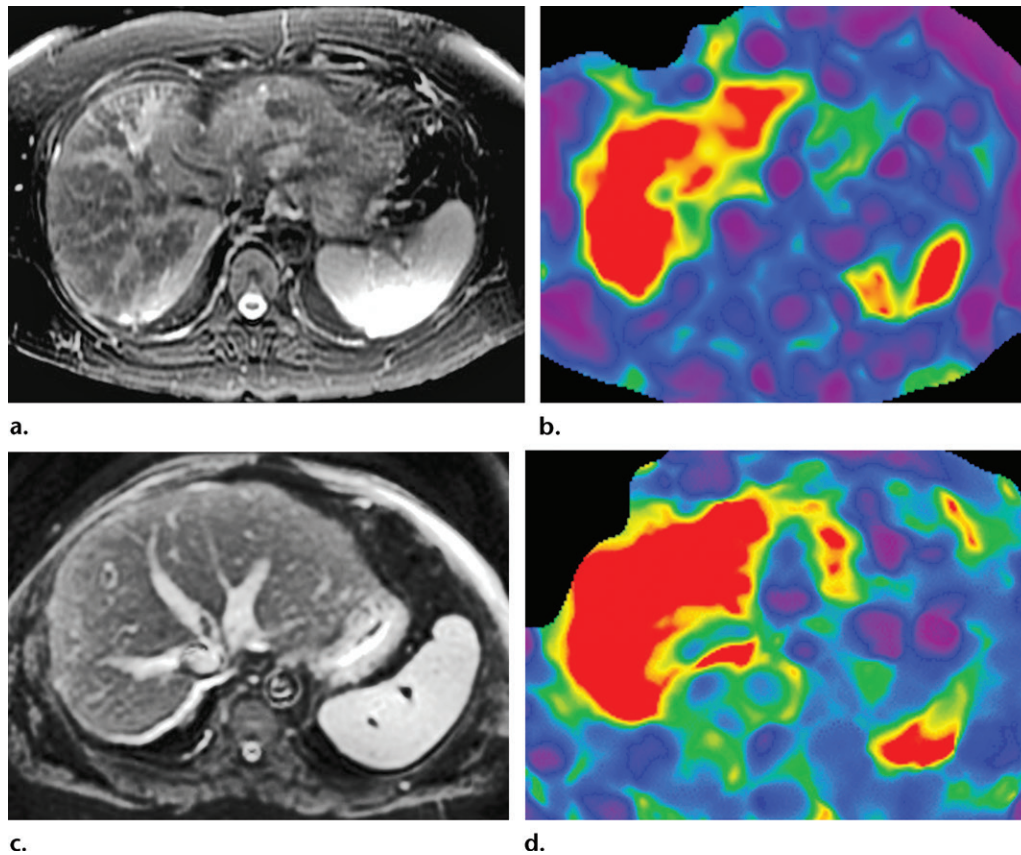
Elevated liver stiffness related to causes other than fibrosis in two patients. (a, b) Axial T2-weighted MR image (a) and color elastogram (b) in a patient with acute hepatitis show patchy edema throughout the liver (a) and diffuse increased liver stiffness (red and orange regions in b). (c, d) Axial T2-weighted MR image (c) and color elastogram (d) in a patient with passive hepatic congestion show dilated hepatic veins (c) and diffuse increased liver stiffness (red and orange regions in d).
